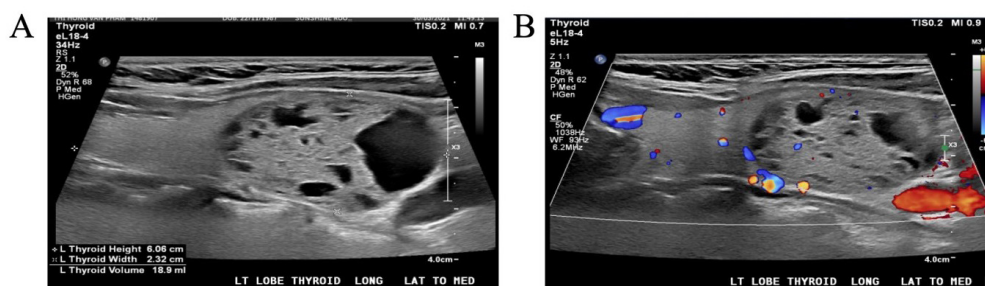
Ultrasound of neck showed a mixed solid/cystic, hyperechoic lesion within the left thyroid lobe (A), with normal vascularity (B).
